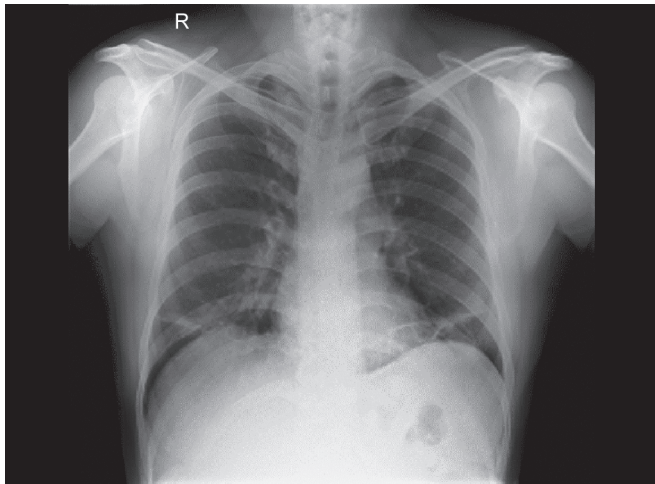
A chest X-ray after anticoagulation and antibiotics
